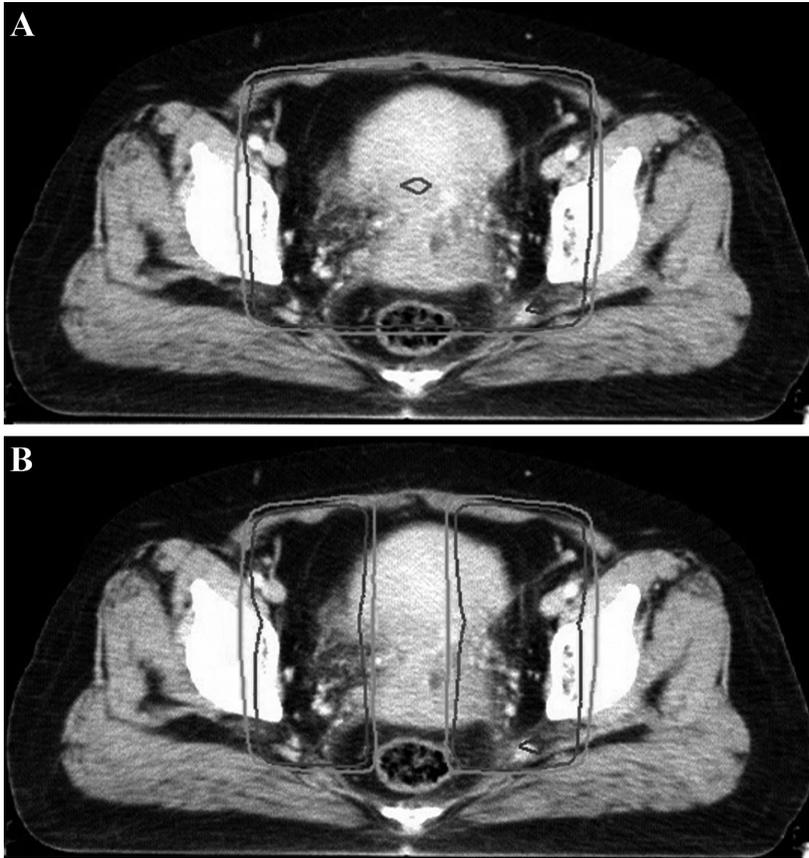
CT imaging of the patient, high-risk clinical target volume (HR-CTV) and organs at risk (bladder and rectum). The 100%- and 95%-isodose lines are shown in red and green colors, respectively. A) Dose of CTV in the first plan (3,600 cGy/20F), B) Total dose of CTV (4,500 cGy/25F).
